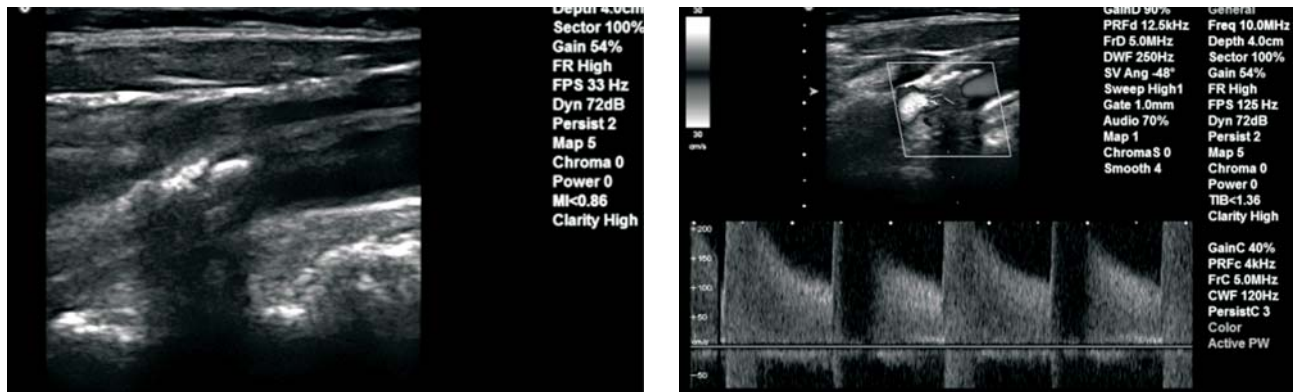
Doppler sonography of left carotid artery – high grade stenosis
